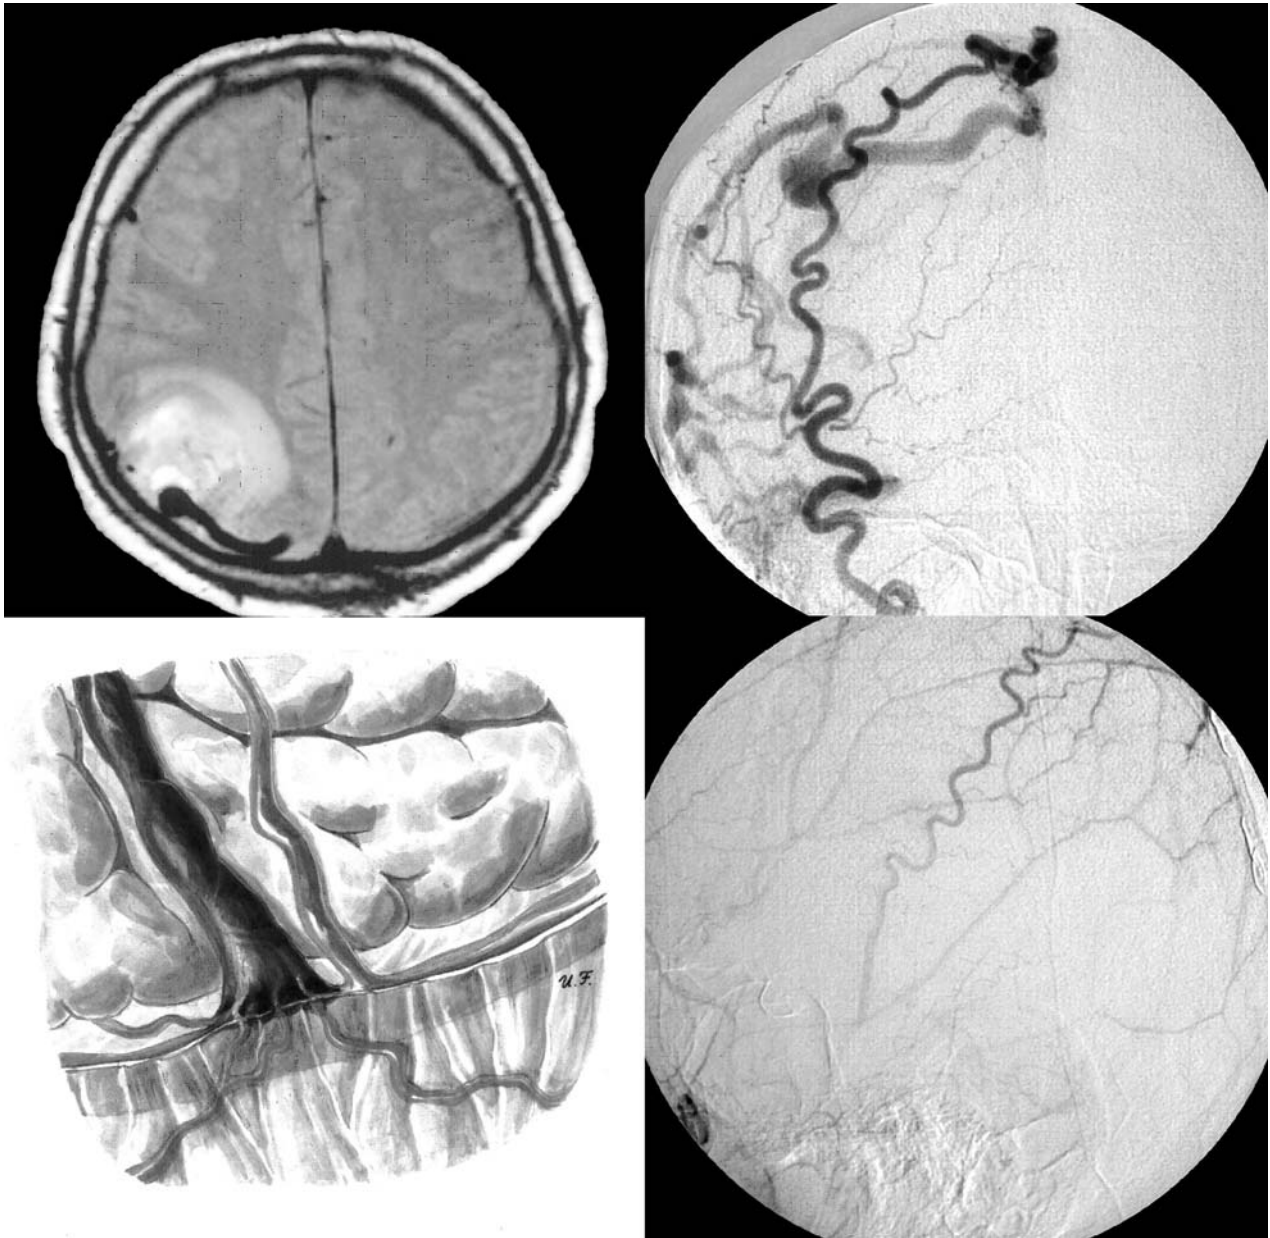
A 59-year-old man presented with sudden headache and hemianopia. MRI showed a right parietal haemorrhage and a dilated bridging vein. Right external carotid angiography showing direct fistula into a varicose leptomeningeal vein and cortical reflux. Outflow of the leptomeningeal vein into the superior sagittal sinus is thrombosed. Intraoperative view after right parietal craniotomy showing multiple dural arteries entering the leptomeningeal vein. Curative therapy consisted of coagulation and division of this vein. Postoperative right external carotid angiography showing elimination of the fistula
